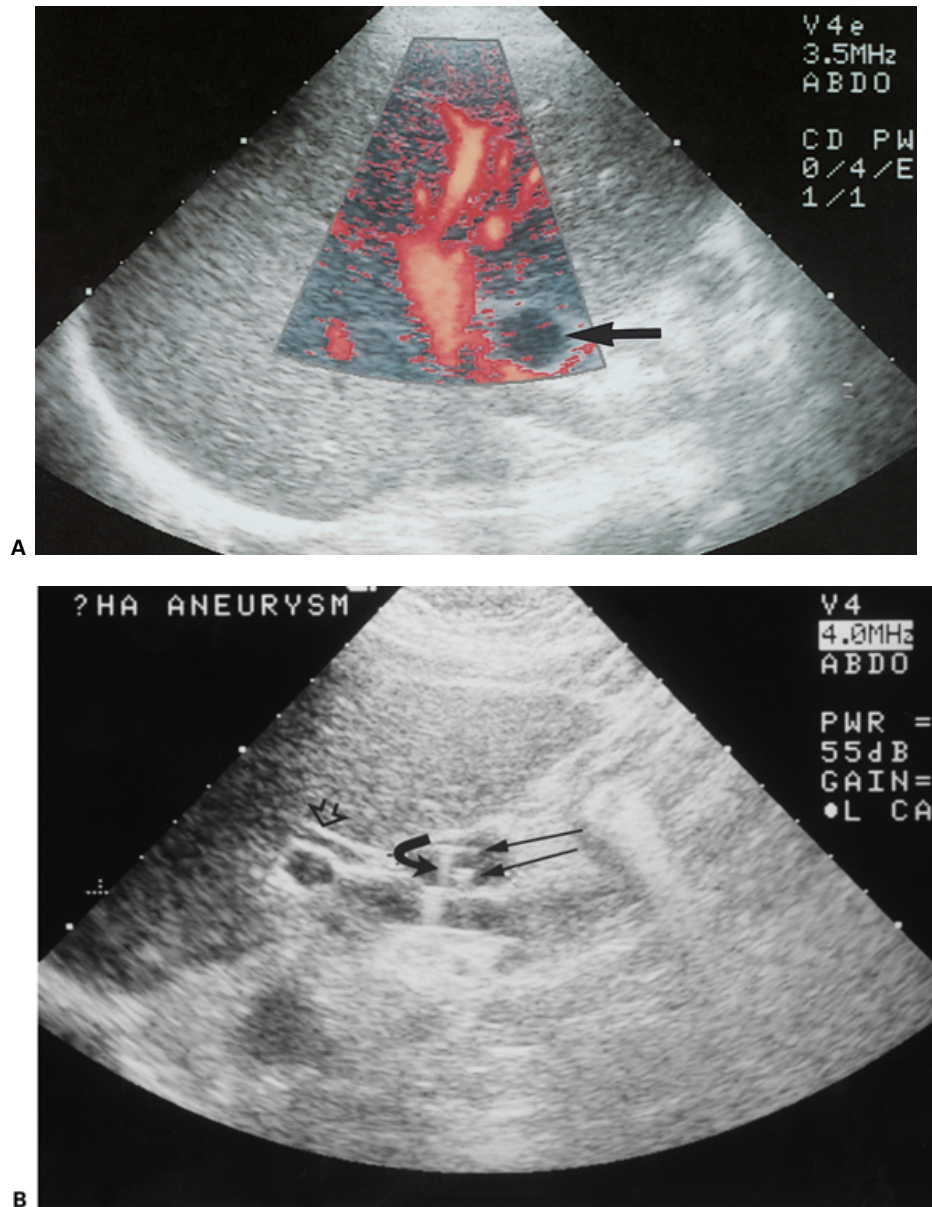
(A) Power Doppler sonogram obtained 2 months after embolization demonstrates absence of flow within the aneurysmal sac (arrow). (B) Gray-scale sonogram obtained during the same follow-up examination shows typical comet-tail artifacts (curved arrow) associated with the metallic intravascular coils (straight arrows). The open arrow points to the common bile duct.
